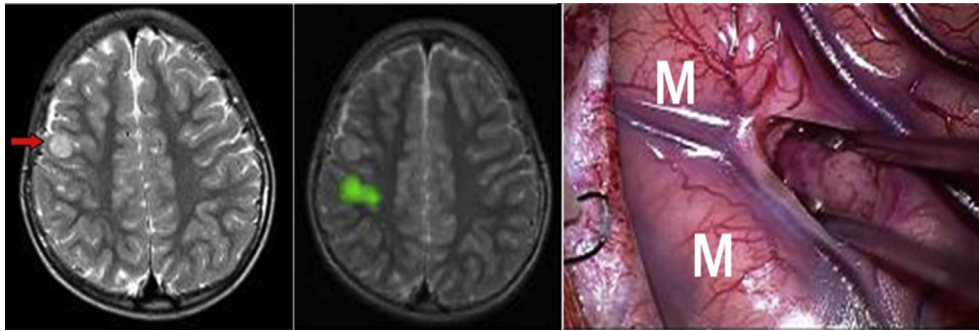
7 year-old boy with small round mass in MRI was referred for surgery due to frequent brief motor seizure, which was removed successfully adjacent right motor area by intraoperative stimulation mapping to confirm motor area (M) under awake. Green dot: motor area in functional MRI.
